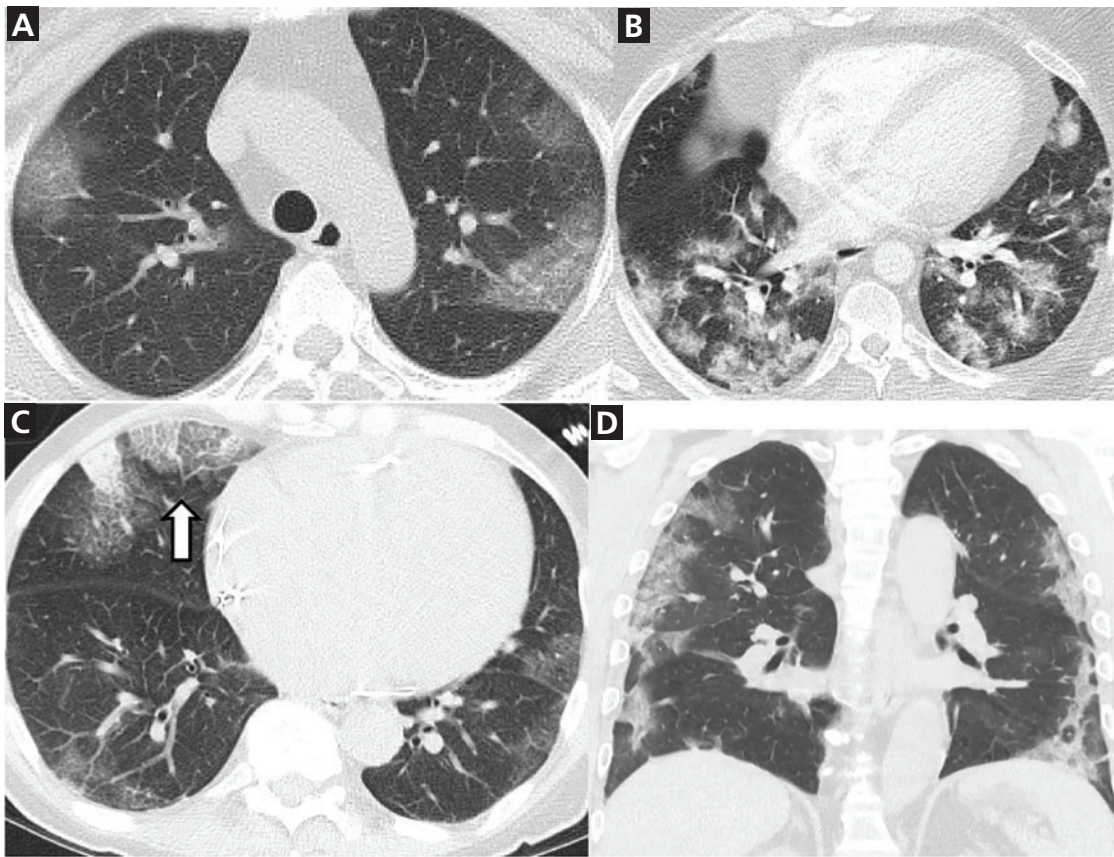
Typical computed tomographic features of COVID-19. Unenhanced axial images of the lungs of 4 different patients with COVID-19 demonstrate bilateral, multifocal, peripheral ground-glass opacities, and consolidation, most with rounded morphology. “Crazy paving” (ground-glass opacities with superimposed interlobular septal thickening and intralobular lines) is seen in (C) (white arrow).
